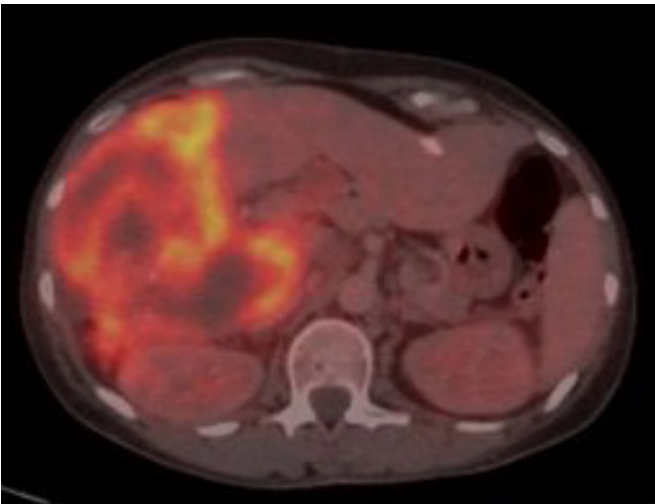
Description of the Figure: PRE-TX PET-CT
